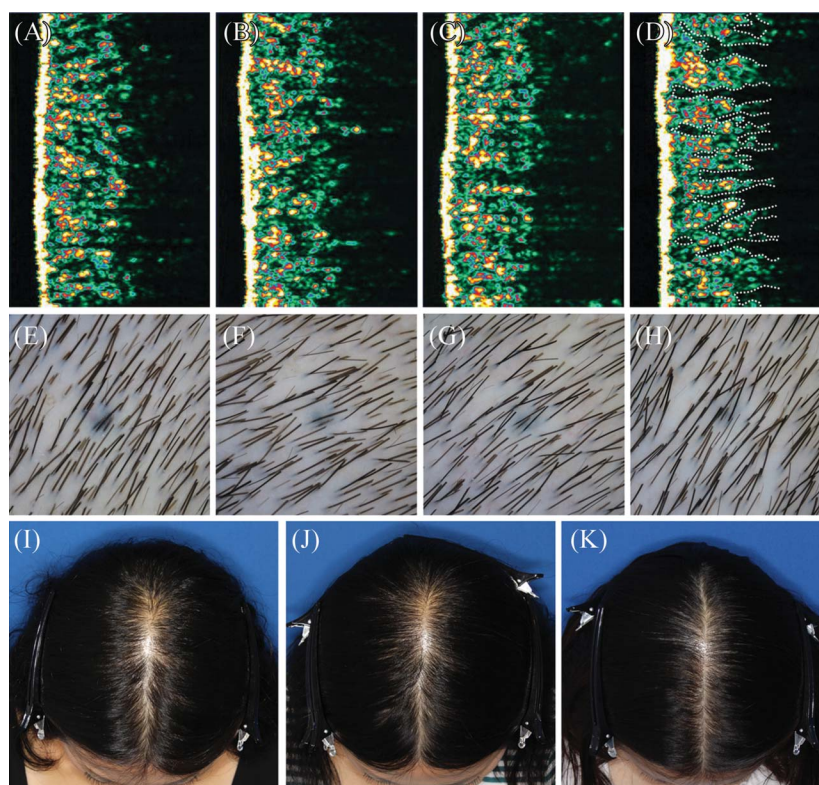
A 37-year-old woman treated with ADSC-CM injection. Upper row shows cross-sectional ultrasonographic images of the right scalp at T0 (A), T2 (B), T4 (C), and T6 (D). Dermal thickness increased from 1.69 mm (A) to 1.75 mm (D). Dermal echogenicity increased from 28.3% (A) to 31.8% (C), then decreased to 25.5% (D). Dotted line represents hair follicles (D). Middle row shows trichoscopic images of the right scalp at T0 (E), T2 (F), T4 (G), and T6 (H). Hair density increased from 143.2/cm² (E) to 149.5/cm² (H). Lower row shows clinical photographs at T0 (I), T6 (J), and 1 year after 8 sessions of treatment (K). ADSC-CM, adipose-derived stem cell-conditioned medium.
